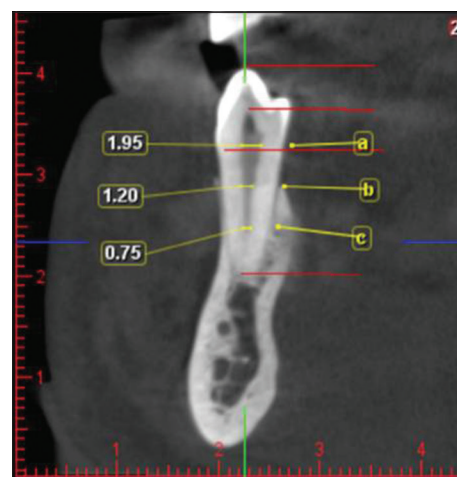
Para axial cone-beam computed tomography scan shows measurements at the level of c: Mid root level, and level b: Midpoint of c and a, root width at level, a: Cement enamel junction
